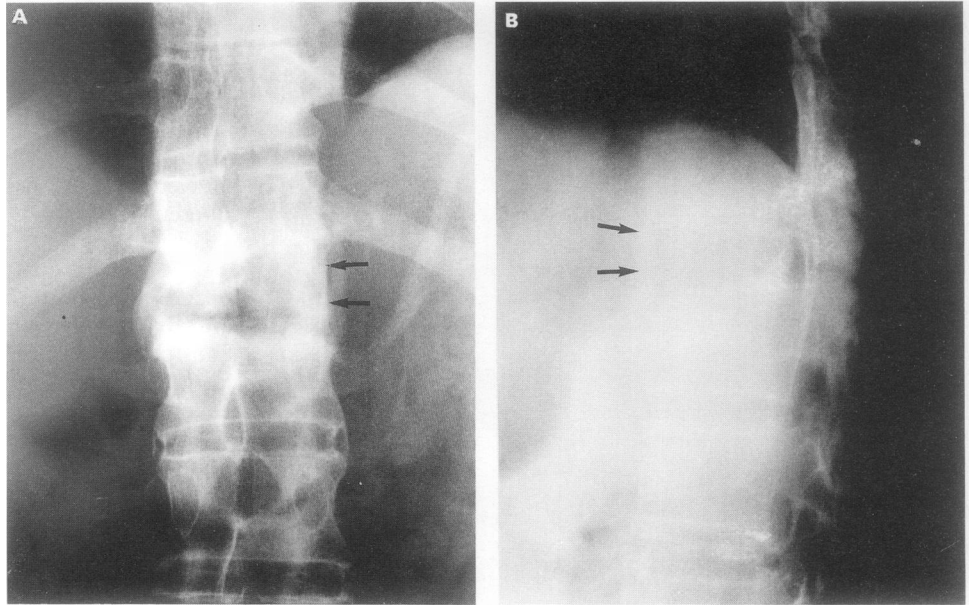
(A) AP and (B) lateral radiograph three weeks after anterior spinal fusion show satisfactory position of bone graft at the T12/L1 space (arrows).
